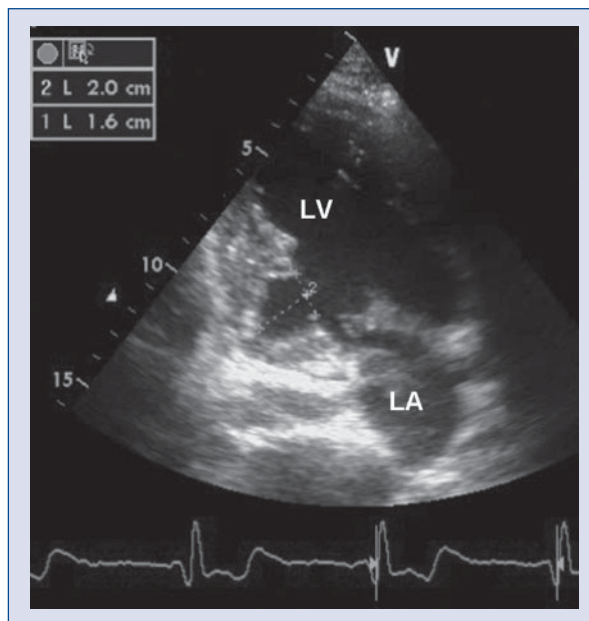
Two-dimensional transthoracic echocardiography. Apical two chamber view showing an inferobasal left ventricular diverticulum during diastole; LA — left atrium; LV — left ventricle.
